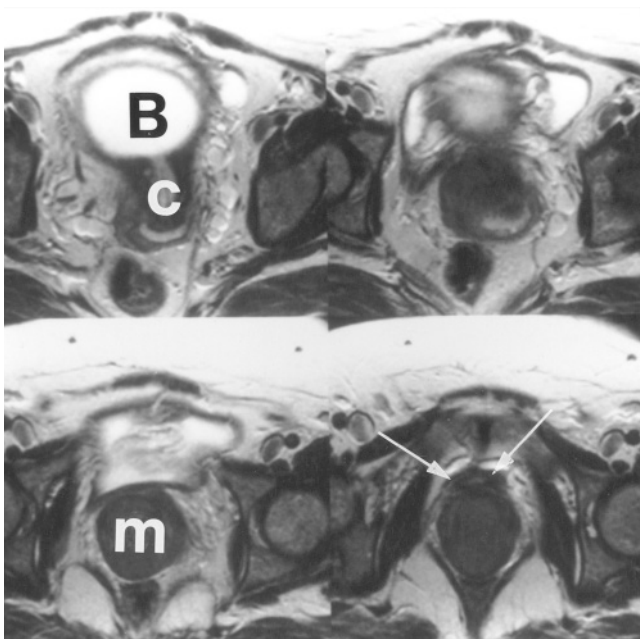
Primary vaginal leiomyoma in a 40-year-old woman. Four consecutive transverse T2-weighted ETSE images show a homogeneous low-signal-intensity mass (m) that is separate from the cervix (c) and urethra (arrows). The low signal intensity on T2 reflects the smooth muscle content of the tumor. B, bladder.
